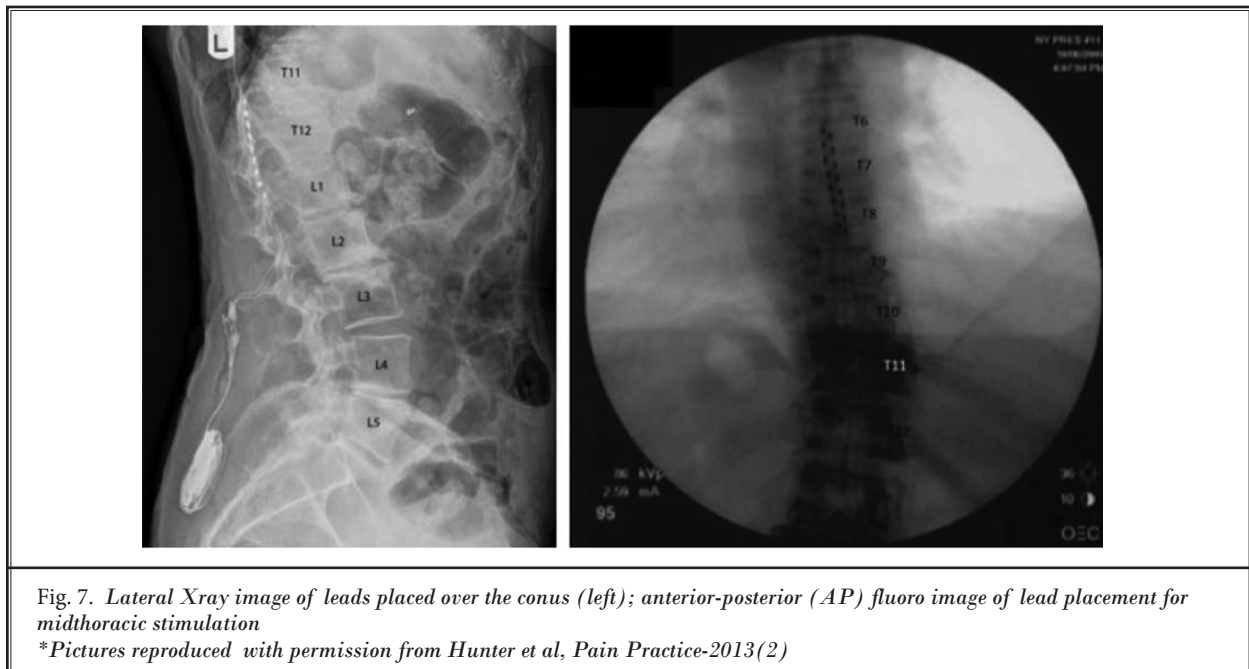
Lateral Xray image of leads placed over the conus (left); anterior-posterior (AP) fluoro image of lead placement for midthoracic stimulation
